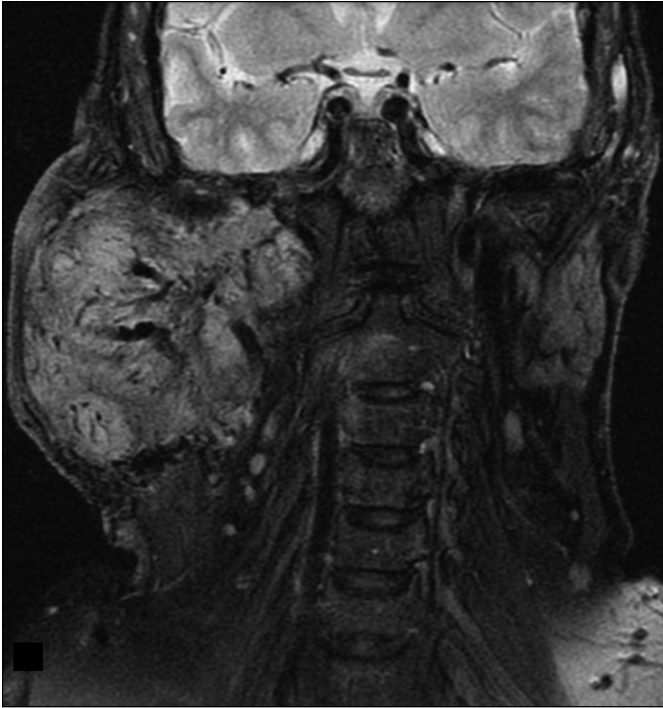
Magnetic resonance imaging of a 9-cm jugular paraganglioma invading the skull base, carotid vessels, and the mastoid part of the temporal bone.
